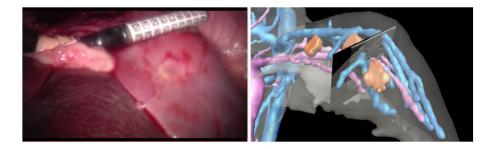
The pre-operative anatomical model derived from CT data is visualized within the context of live laparoscopic video and ultrasound data [31].
